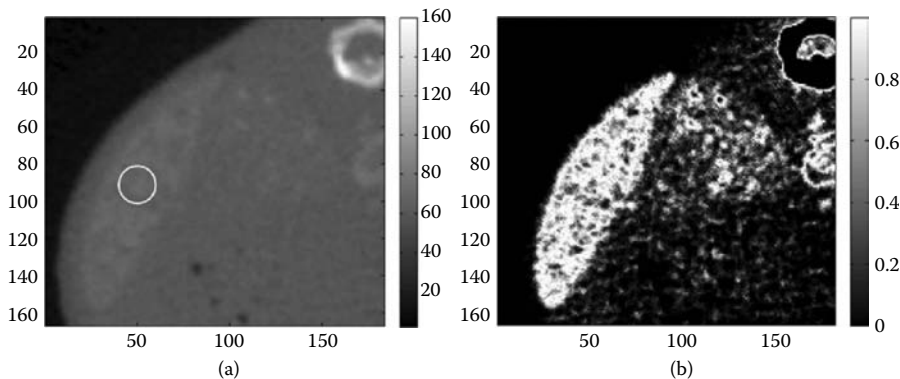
Example of raw data and corresponding likelihood image. (a) Grayscale image of raw CT data containing a portion of the spleen. The small circle in the spleen region surrounds a manually marked seed point used to initialize our semiautomatic segmentation process. (b) Likelihood image corresponding to raw data from (a). A two-component Gaussian mixture is estimated from the seed region. The resulting higher mean component represents the spleen blood pool and is used to compute the likelihood image.
